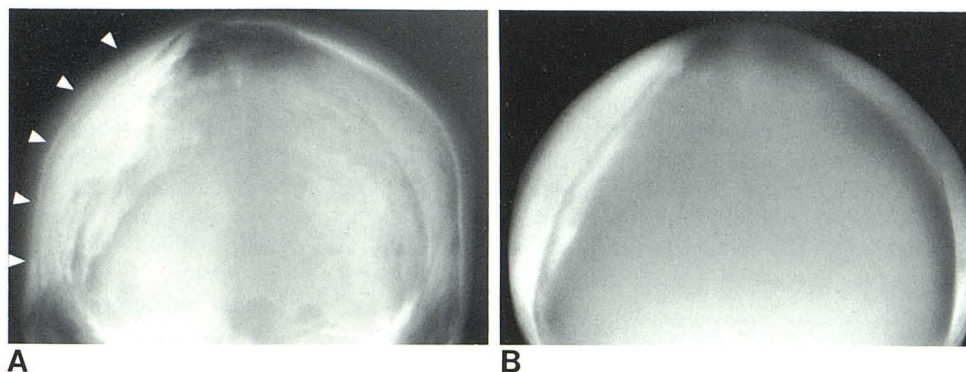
Case 4. Basal (A) and lateral (B) polytomograms. Diffuse, dense hyperostosis of left sphenoidal wings. Thin subdural layer of calcium or bone density along hyperostotic bone with dural lucent interface. C, Axial high-resolution CT scan at bone window setting. Thin subdural layer of calcium or ossification separated from hyperostotic bone by dural lucent line.
